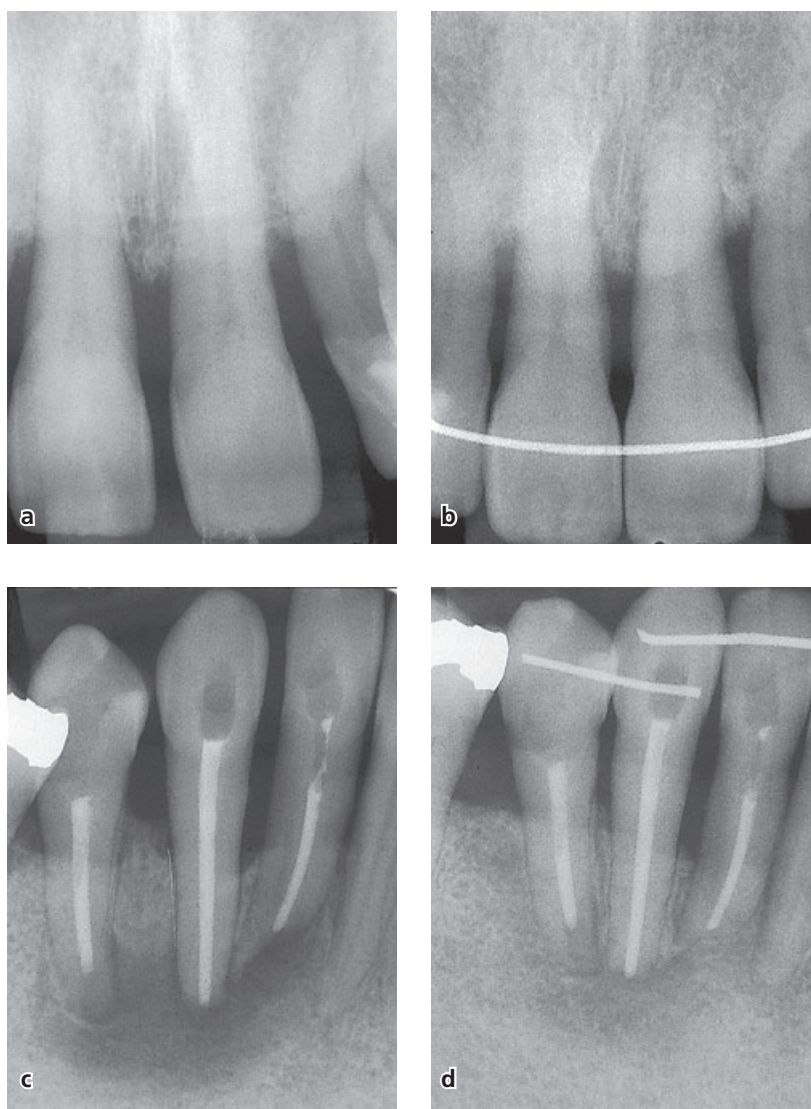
Long-term radiographic follow-up of the same patient as in Fig. 57-1. Radiographs of maxillary and mandibular anterior regions 7 years after the completion of orthodontic therapy (b,d) show reduced but healthy periodontium, with no progression of periodontal tissue destruction compared with the initial situation (a,c).
